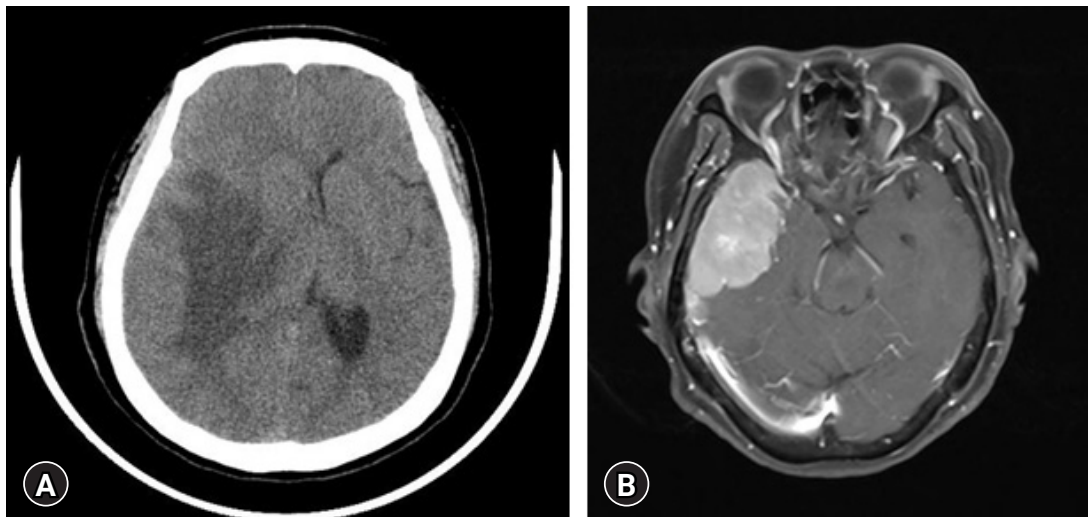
Preoperative image. (A) Contrast-enhanced computed tomography shows a mass in the right temporal lobe with peripheral vasogenic edema. (B) Gadolinium-enhanced T1-weighted magnetic resonance images show a strong, homogenous large mass in the right temporal lobe.
